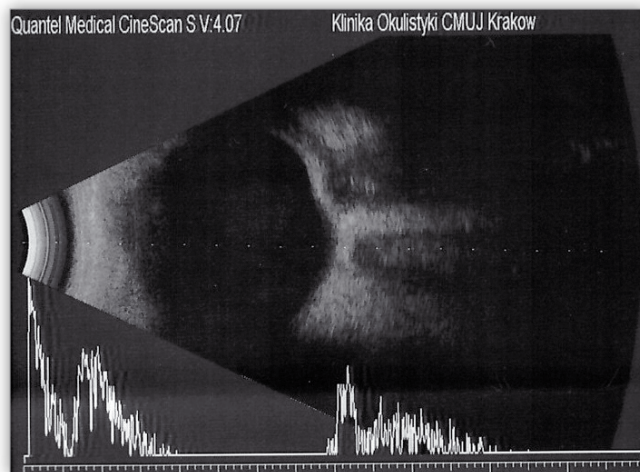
Ultrasound of the left eye following AJL macular buckle implantation.
